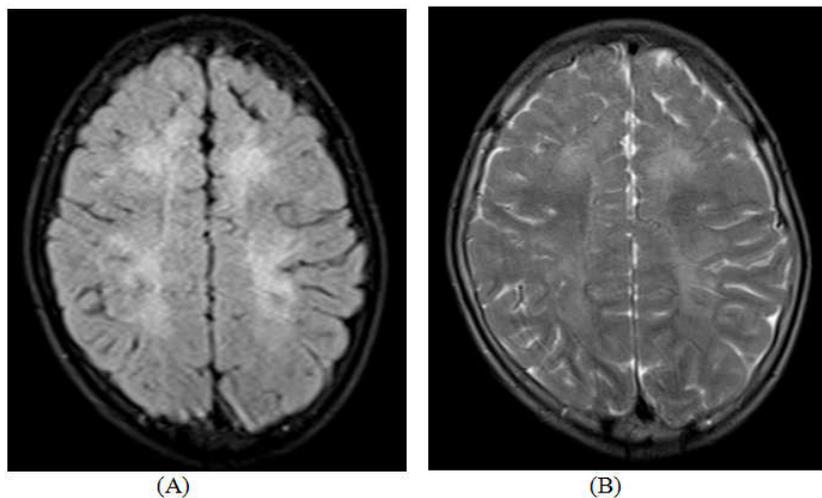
Sub-cortical and periventricular hyperintensities (A) T2 FLAIR, axial (B) T2WI axial
